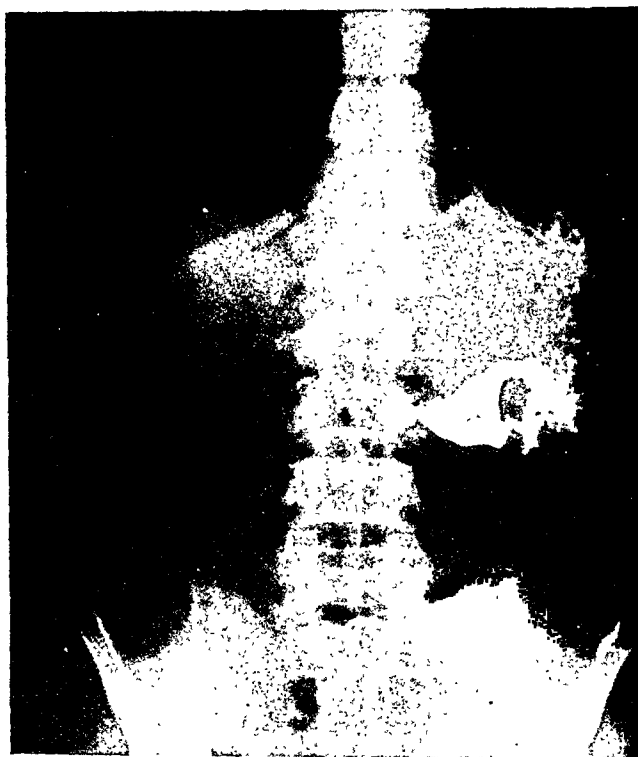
Fig II — Roentgenogram of stomach, 20 June 1945.
